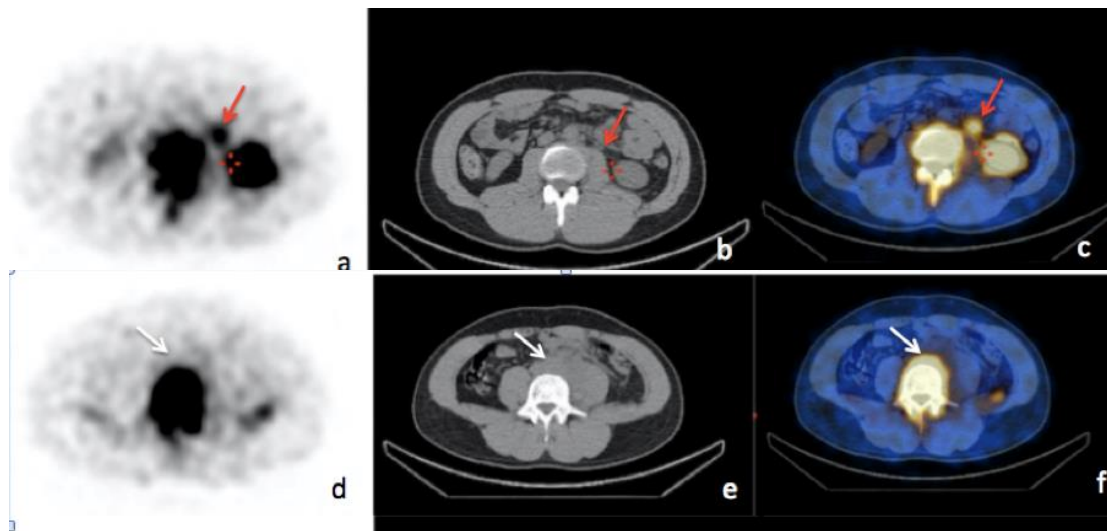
The dilated left ureter and radioactivity stasis were detected on the SPECT/CT sections (Fig 2 a, Fig 2 b, Fig 2 c). The subsequent caudal sections of non-diagnostic CT images show a soft tissue mass surrounding the ureter in the aortocaval region (Fig 2 d, Fig 2 e, Fig 2 f).
